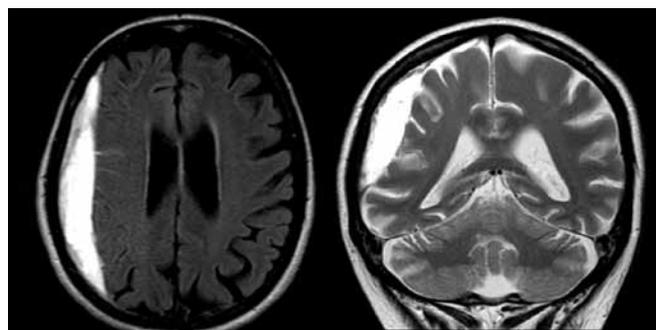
Cerebral MR with axial FLAIR sequences and T2 information. 65-year-old patient with demential syndrome ongoing for several weeks. A right frontoparietal extraaxial hematic accumulation is observable, corresponding to a subacute subdural hematoma.
